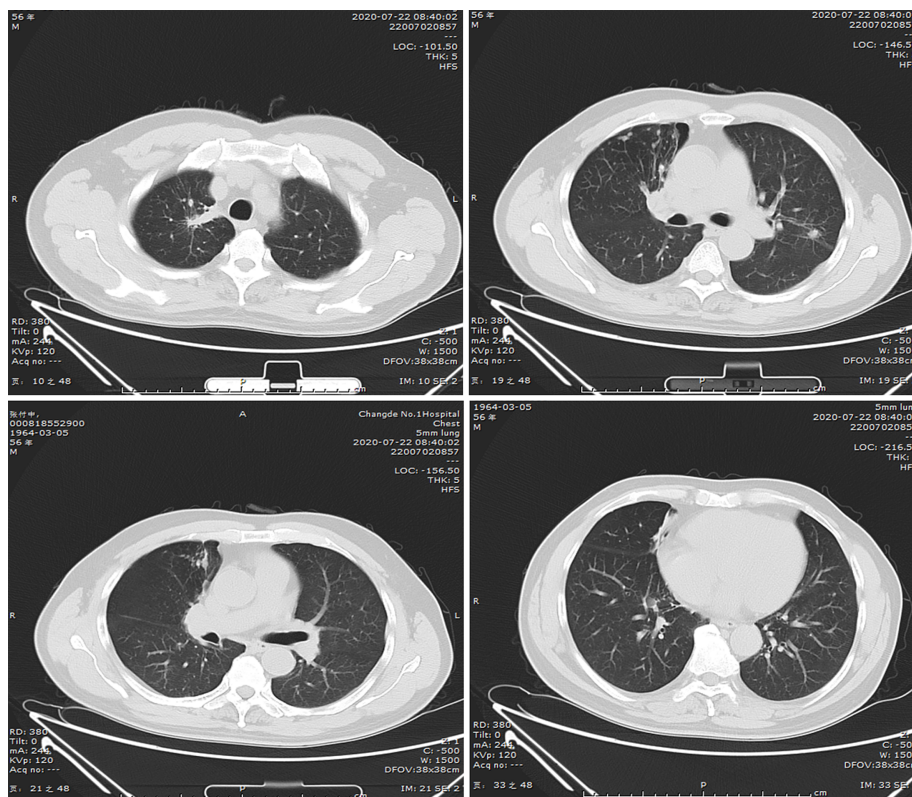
No new lesions were detected on computed tomography follow-up one year after treatment discontinuation.
